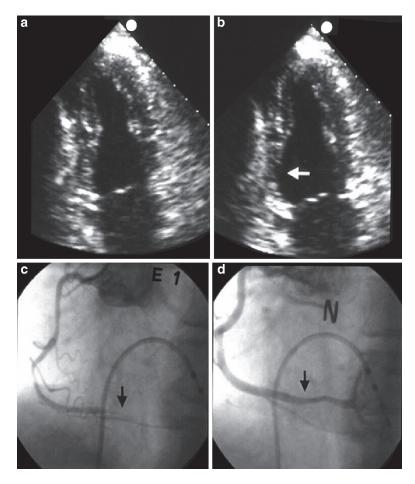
Representative example of ergonovine echocardiography (\mathbf{a}, \mathbf{b}) and invasive spasm provocation testing during diagnostic coronary angiography (\mathbf{c}, \mathbf{d}) in a 47-year-old man. Left ventricular wall motion at end-systole recorded in the apical two-chamber view was demonstrated (\mathbf{a}, \mathbf{b}) . Compared with the basal status (\mathbf{a}) , prominent loss of systolic thickening in the inferior wall developed with an ergonovine dose of 0.15 mg $(\mathbf{b}, white arrow)$, which was compatible with myocardial ischemia due to coronary artery spasm in the right coronary artery territory. Coronary angiogram taken 3 days later revealed no significant fixed disease. Intravenous injection of ergonovine (E1) provoked total occlusion of the distal right coronary artery and relief of total occlusion (\mathbf{d}) . (Adapted from [16], with permission)
